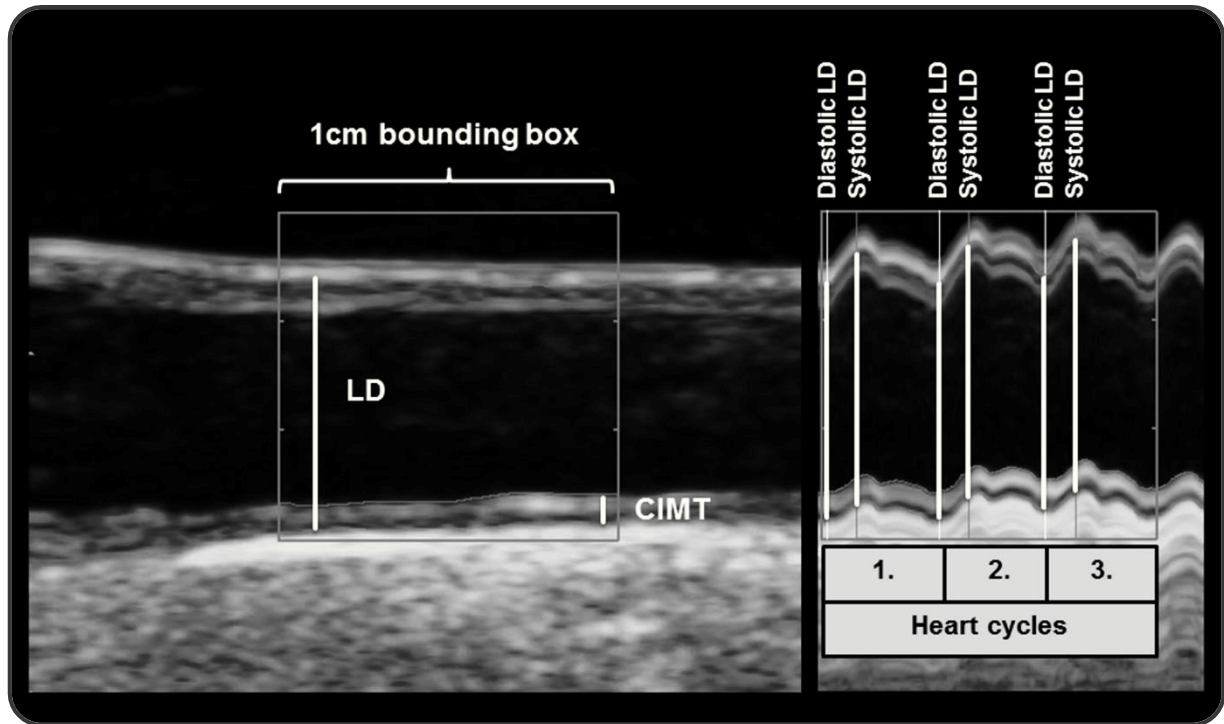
Ultrasound images of the common carotid artery
